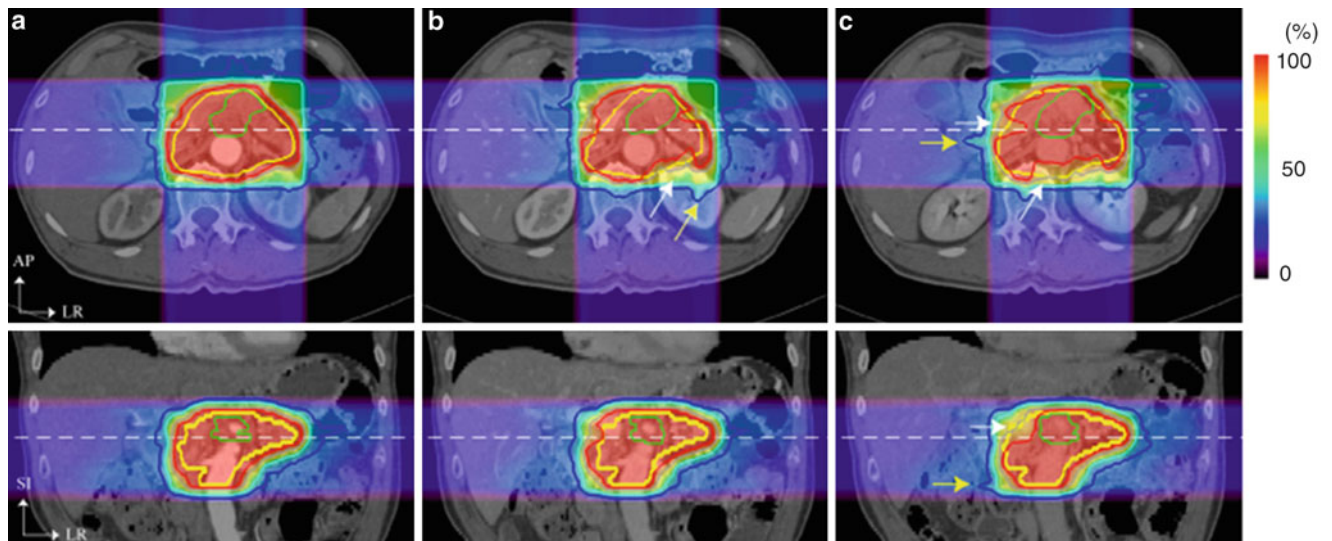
Carbon ion beam distribution in axial and coronal sections (patient no. 1). Time of (a) 0 s (planning CT), (b) 35 s, and (c) 145 s. Beam overshoot (yellow arrows) and undershoot (white arrows) were observed at the scan interval time of 35 and 145 s. Green and yellow lines show GTV and CTV contours, respectively. Red, pink, light-blue, and blue lines show 95, 80, 50, and 30 % of doses, respectively [6]. By permission of Elsevier
